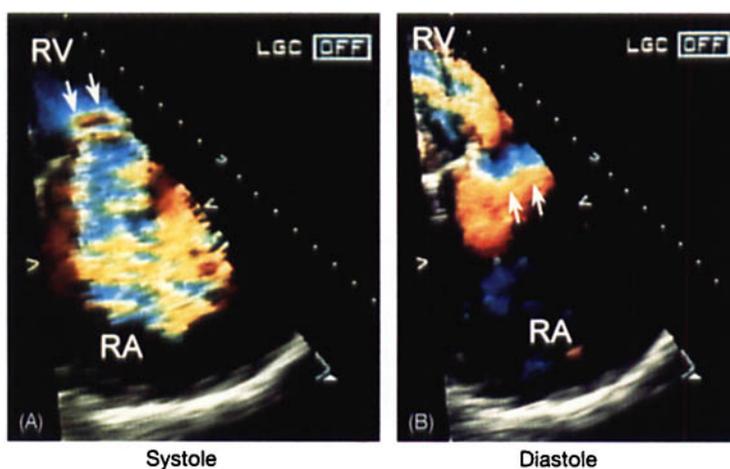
Transthoracic echocardiography of right ventricular inflow view. (A) Color flow image shows severe tricuspid regurgitation. Note the prominent proximal flow convergence at the ventricular surface of the tricuspid leaflets (arrow) during systole. (B) Prominent proximal flow convergence was noted at the atrial surface of the tricuspid leaflets (arrow) during diastole, indicating significant tricuspid stenosis. RA = right atrium, RV = right ventricle.
